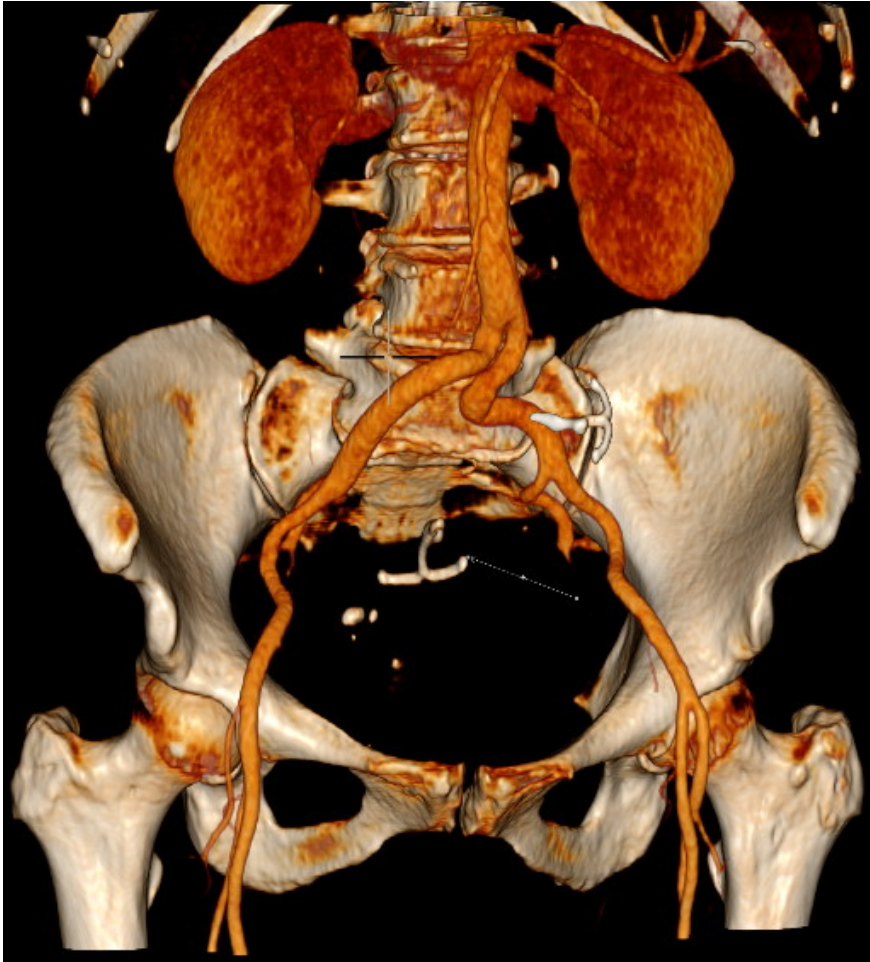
Multiplanar 3D reconstruction of computed tomography showing both intrauterine devices.
